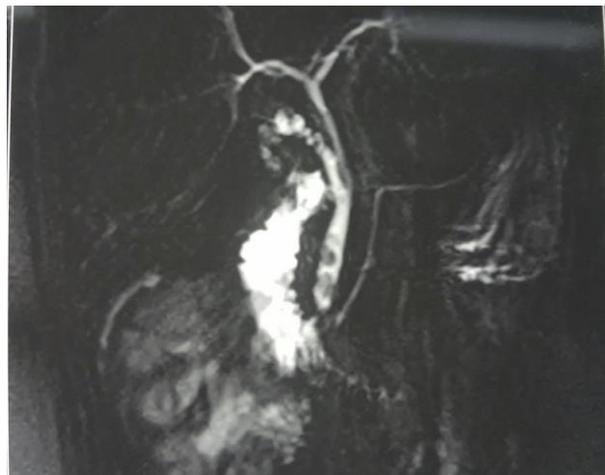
MRI showing two incomplete images of the lower bile duct in relation to calculations
